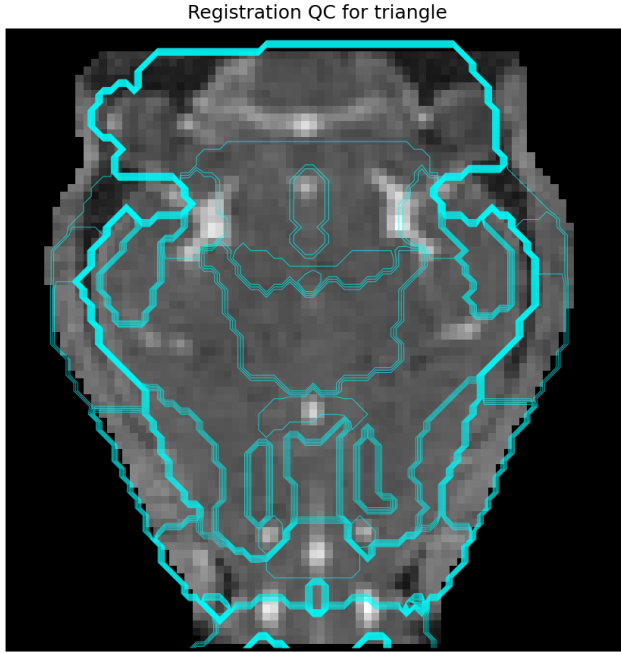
Quality control plot demonstrating the accurate co-registration of the anatomical brain atlas (cyan contours) onto a representative b0-weighted MRI scan of an Egyptian fruit bat. This visual confirmation ensures the precise anatomical alignment necessary for reliable regional brain morphometric feature extraction.
